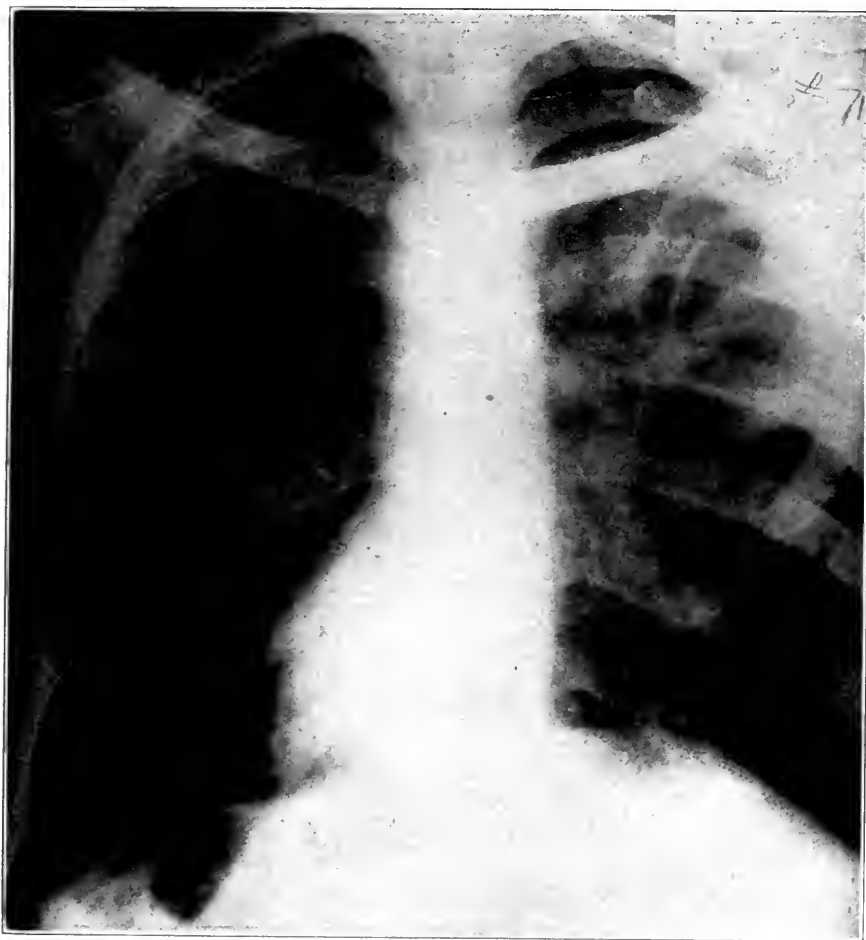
Case 71. Roentgenogram of lungs in a fairly early case. There is typical pleural thickening on the right side with annular shadow, not circular. This roentgenogram demonstrates a stage in the development of pleural annular shadows.
